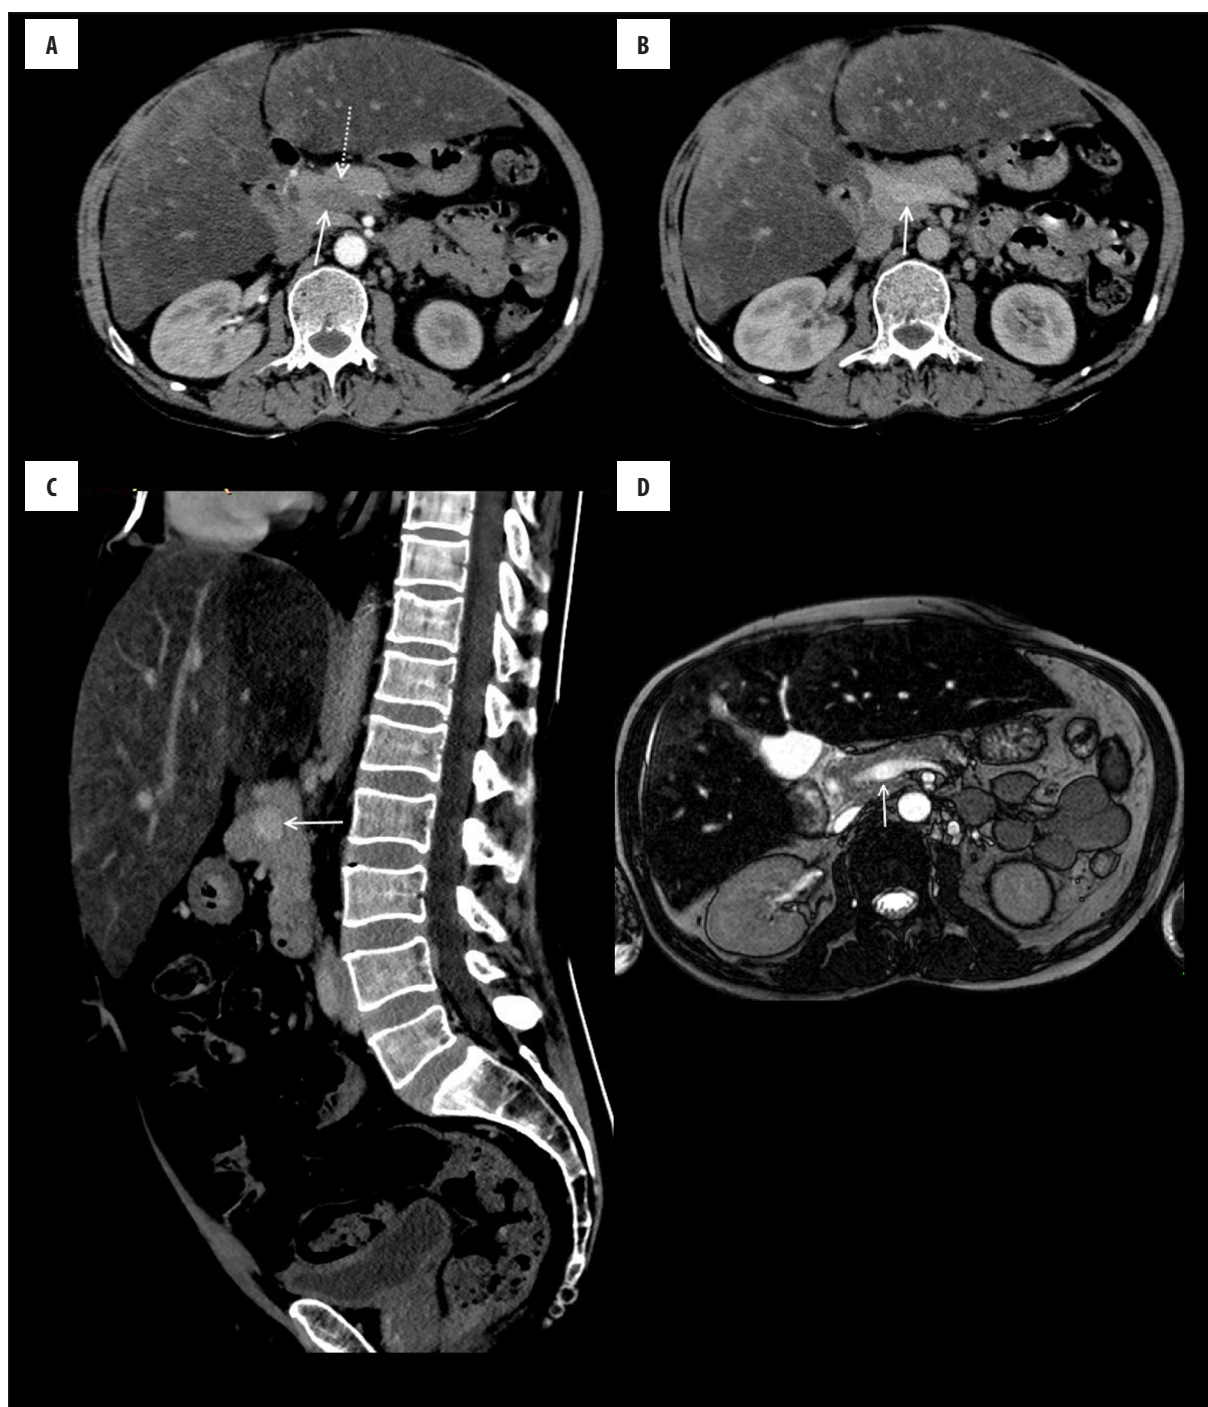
Axial arterial phase (A) and portal venous phase (B) and sagittal portal venous phase (C) CECT images showing a complete intrapancreatic course of the portal vein (white arrows). Pancreatic duct is seen to course anteriorly to the portal vein (dotted white arrow in A). Axial BTFE MR image (D) also shows a complete intrapancreatic course of the portal vein.
